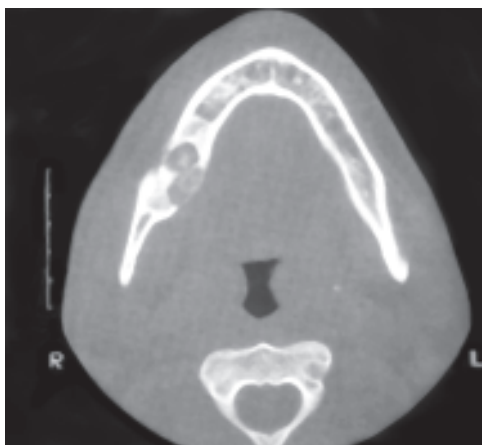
Showing the spherical to ovoid, well-demarcated, mixed radiolucent-radiopaque mass typical of an ossifying fibroma seen on CT scans
